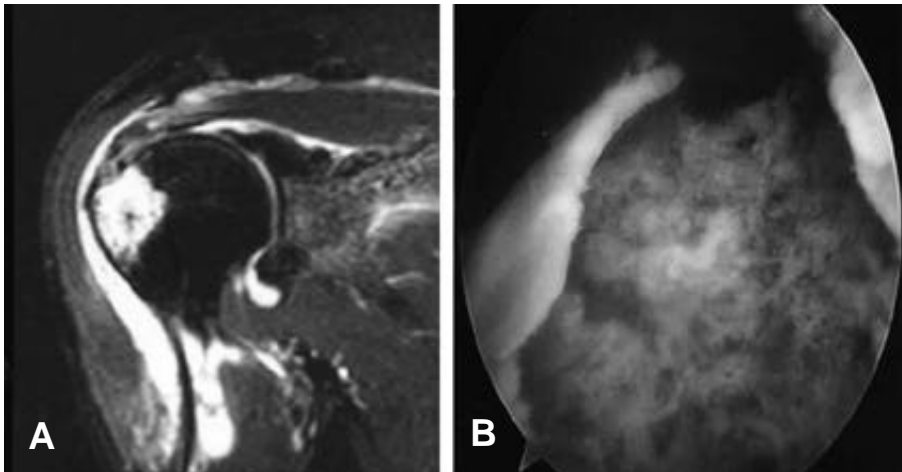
A 55 years old patient with septic shoulder after local injection. Reactive bone marrow edema in the great tuberosity demonstrates increased signal intensity at T2-weighted image. The size of marrow edema varies but localizes within the superolateral quarter of the head(A). Arthroscopic view on the superolateral aspect: articular cartilage detachment from the periphery of the head and subchondral bone is exposed(B).
